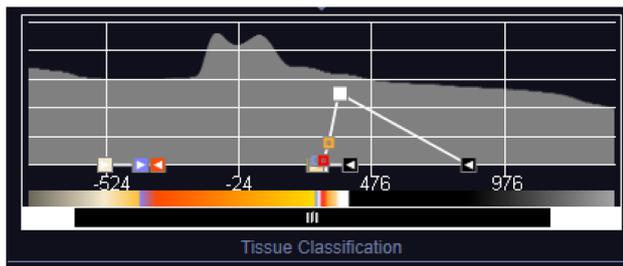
A 73-year-old man with left ureteropelvic junction UTUC. a Axial 2D CT image in the delayed/excretory phase demonstrates excreted contrast surrounding a papillary filling defect consistent with the patient's known disease (red arrow). b Coronal VR image, also in the delayed/excretory phase, also demonstrates the filling defect (red
